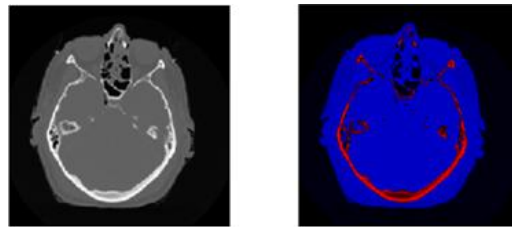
3 RGB Cube pseudocolor map of CT image
